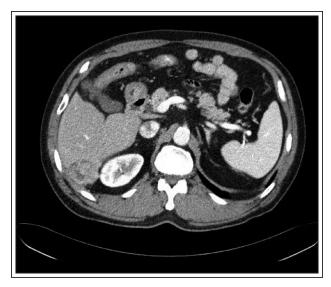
Computed tomography scan showing enhancing mass on the liver concerning for a hepatocellular carcinoma.
